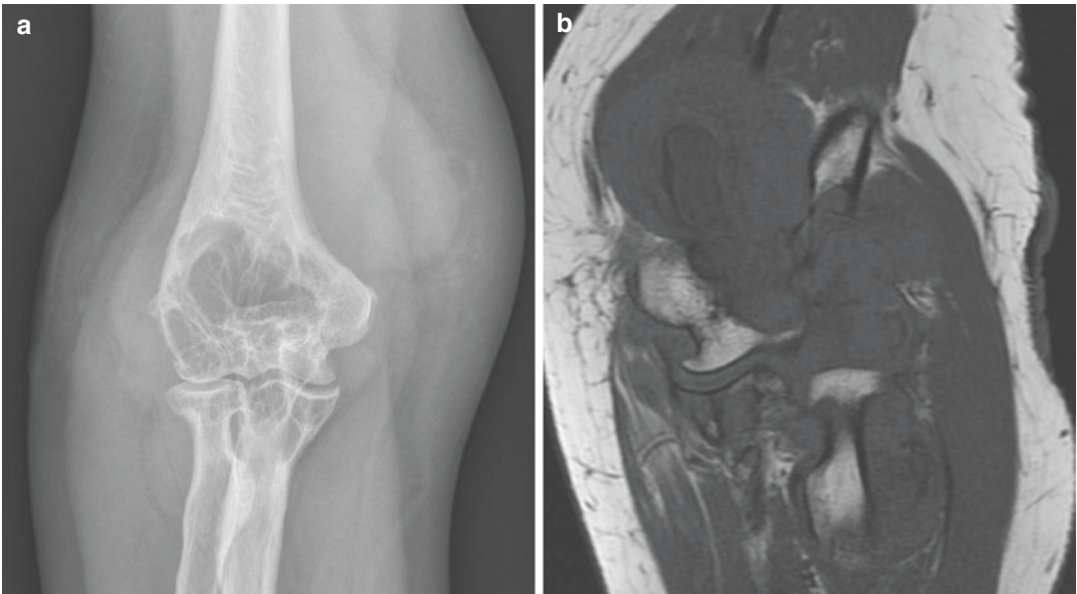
Tenosynovial giant cell tumor, diffuse type. Radiograph (a) shows multilobulated soft tissue mass around the elbow. Extensive bone erosion is seen, but the joint spaces are preserved and perilesional bone density is normal. The lesions are isointense on coronal T1WI (b), with small dark signal foci. A heterogeneous signal is
